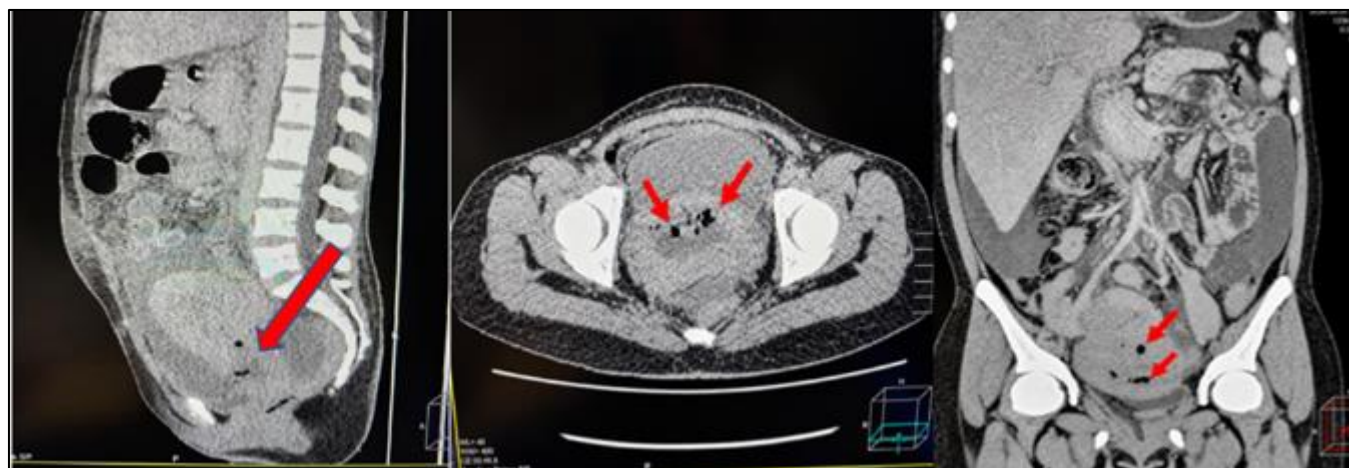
Computed tomography of the abdomen and pelvis in different planes, showing the presence of intrauterine gas located in the endometrial cavity, indicated by red arrows, associated with uterine inflammatory changes compatible with puerperal endometritis.
